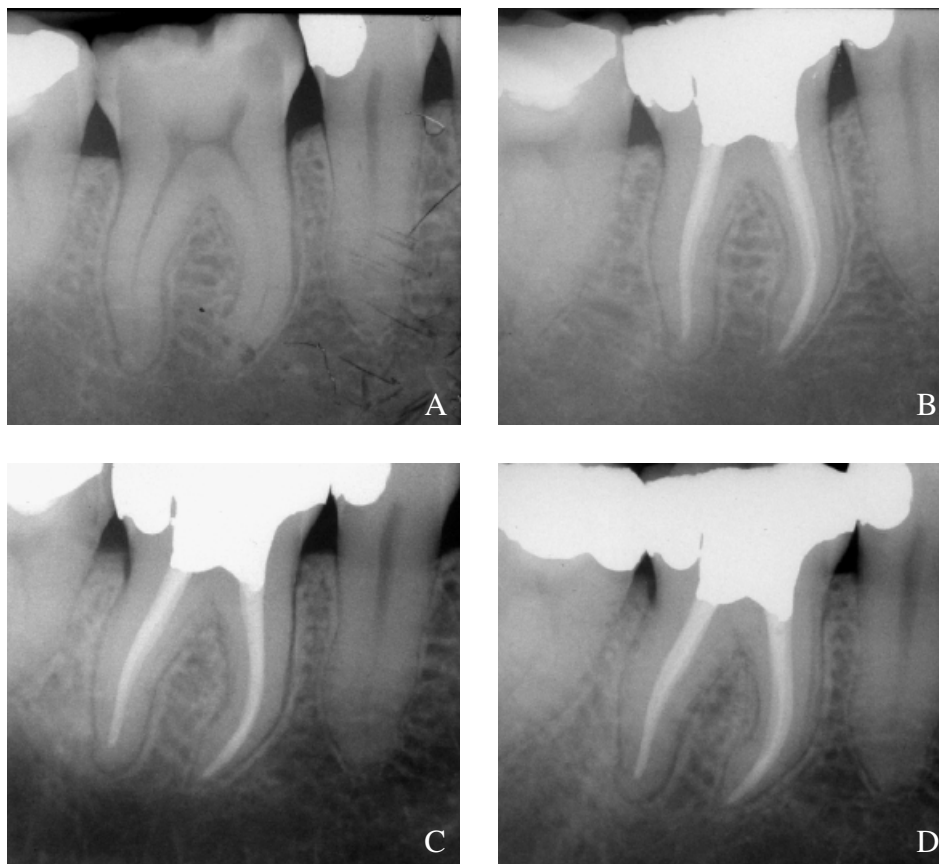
Pulpectomy of tooth #46 following a carious exposure of the pulp. (A) Preoperative radiograph. (B) Immediate postoperative control demonstrating adequate length and density of filling. (C and D) Two- and 3-year postoperative control radiographs, respectively, show normal periapical bone structures.
